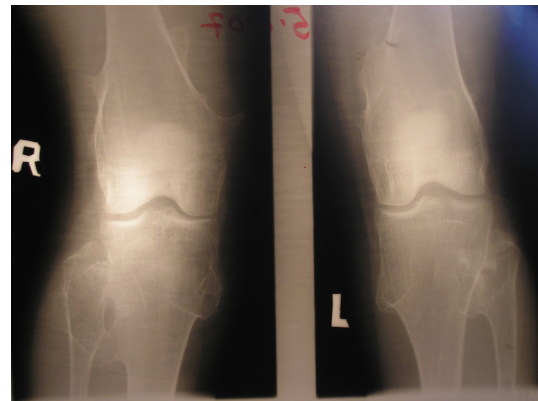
Knee X-ray showing the bilateral localization of exostoses.
